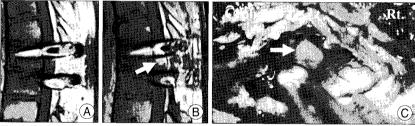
Contrast enhanced T1 weighted magnetic resonance images: before (A) and after (B) first recurrence. Tumor is located in right side of the spinal cord (C).
